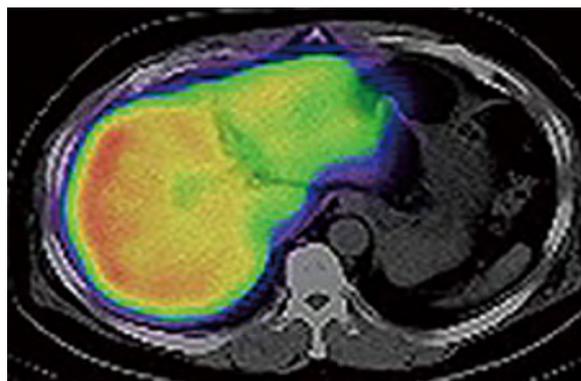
Computed tomography/<sup>99m</sup>Tc-galactosyl human serum albumin single-photon emission computed tomography fusion image in a 58-year-old male with early gallbladder cancer. The uptake of <sup>99m</sup>Tc-galactosyl human serum albumin was markedly decreased in the interior portion of the left lobe. This computed tomography image was at the level of the center of the left lobe, and was neither the cranial edge nor the caudal edge of that lobe.
